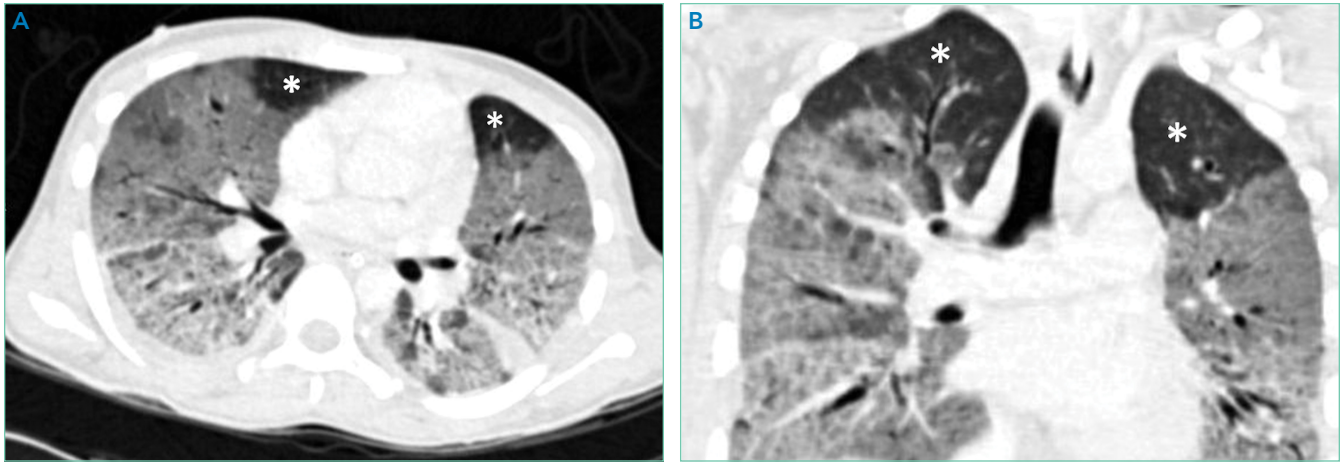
Axial (A) and coronal (B) computed tomography of the thorax showing extensive ground-glass opacities and consolidation sparing the nondependent portions of the lungs (apices and anterior segments, asterisks).
